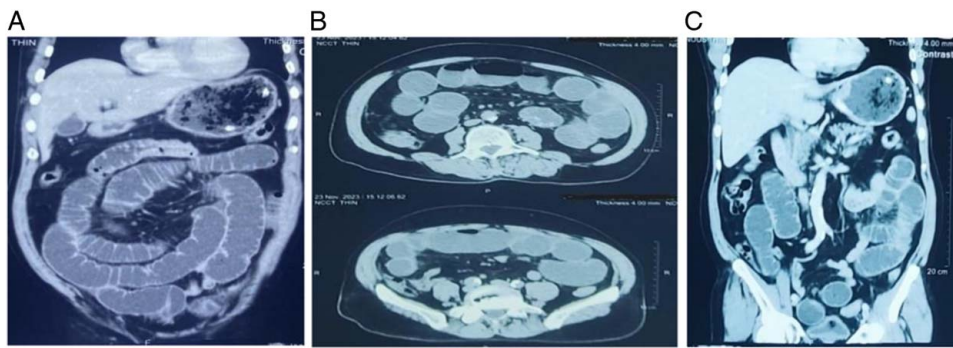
Contrast-enhanced CT scan (CECT) of abdomen and pelvis suggestive of small bowel obstruction.
